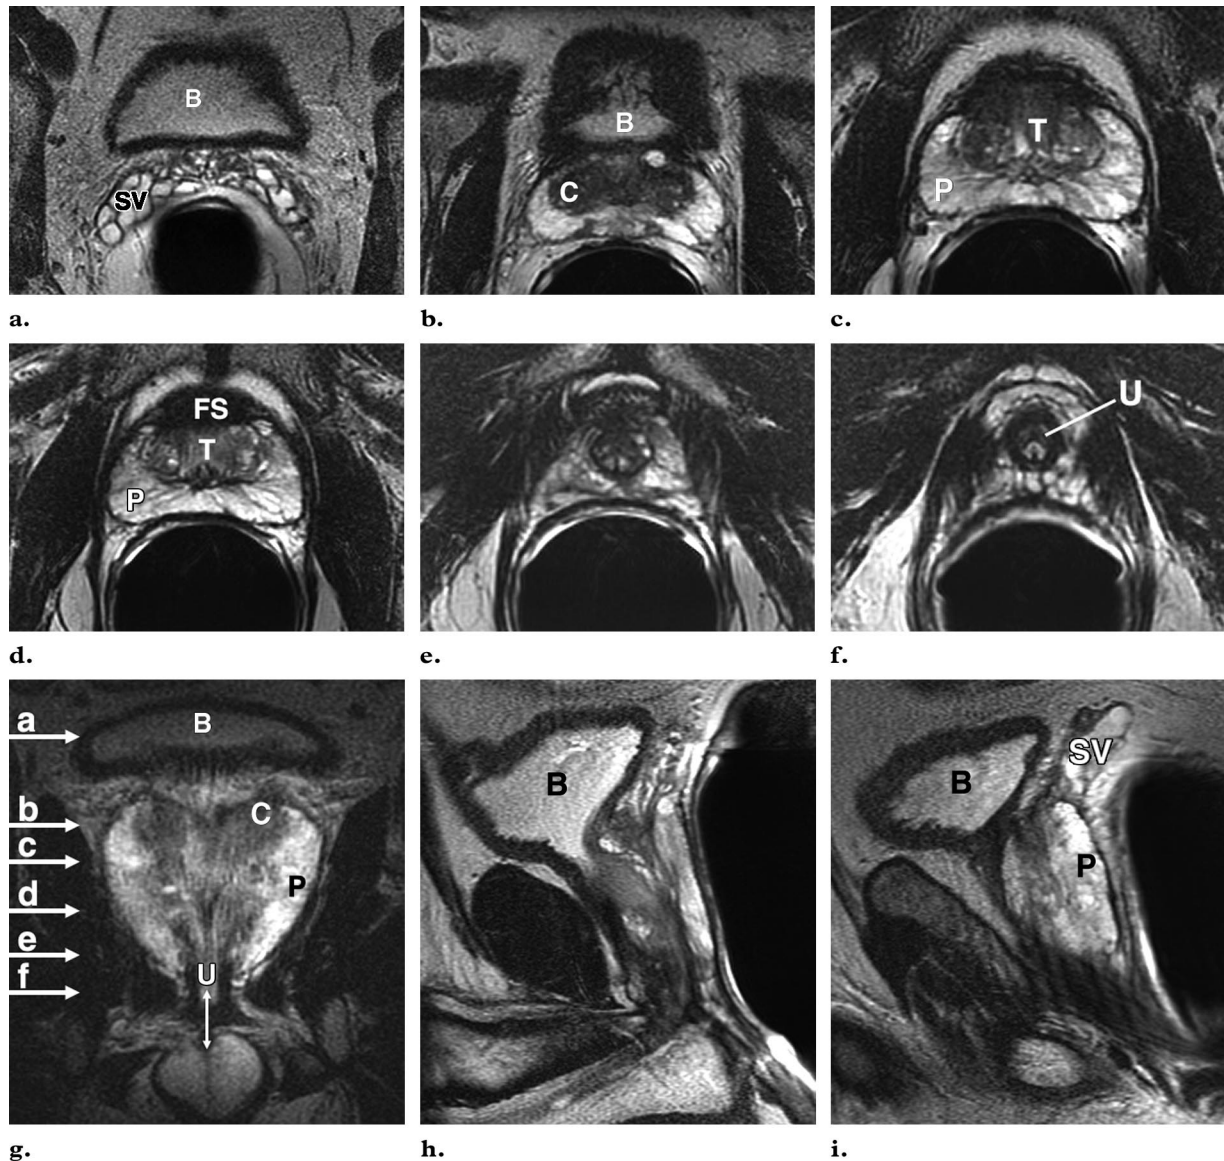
Normal prostate zonal anatomy in a 60-year-old man depicted with T2-weighted axial MR images obtained at the level of the seminal vesicles (a), the base of the prostate (b), the mid-gland (c, d), the apex (e), and the membranous urethra (f), as well as coronal (g), midsagittal (h), and parasagittal (i) MR images. The letters in g correspond to the anatomic levels used for images a-f. The vertical line in g indicates the membranous urethral length. *B* = urinary bladder, *C* = central zone, *FS* = anterior fibromuscular stroma, *P* = peripheral zone, *SV* = seminal vesicles, *T* = transition zone, *U* = urethra.
